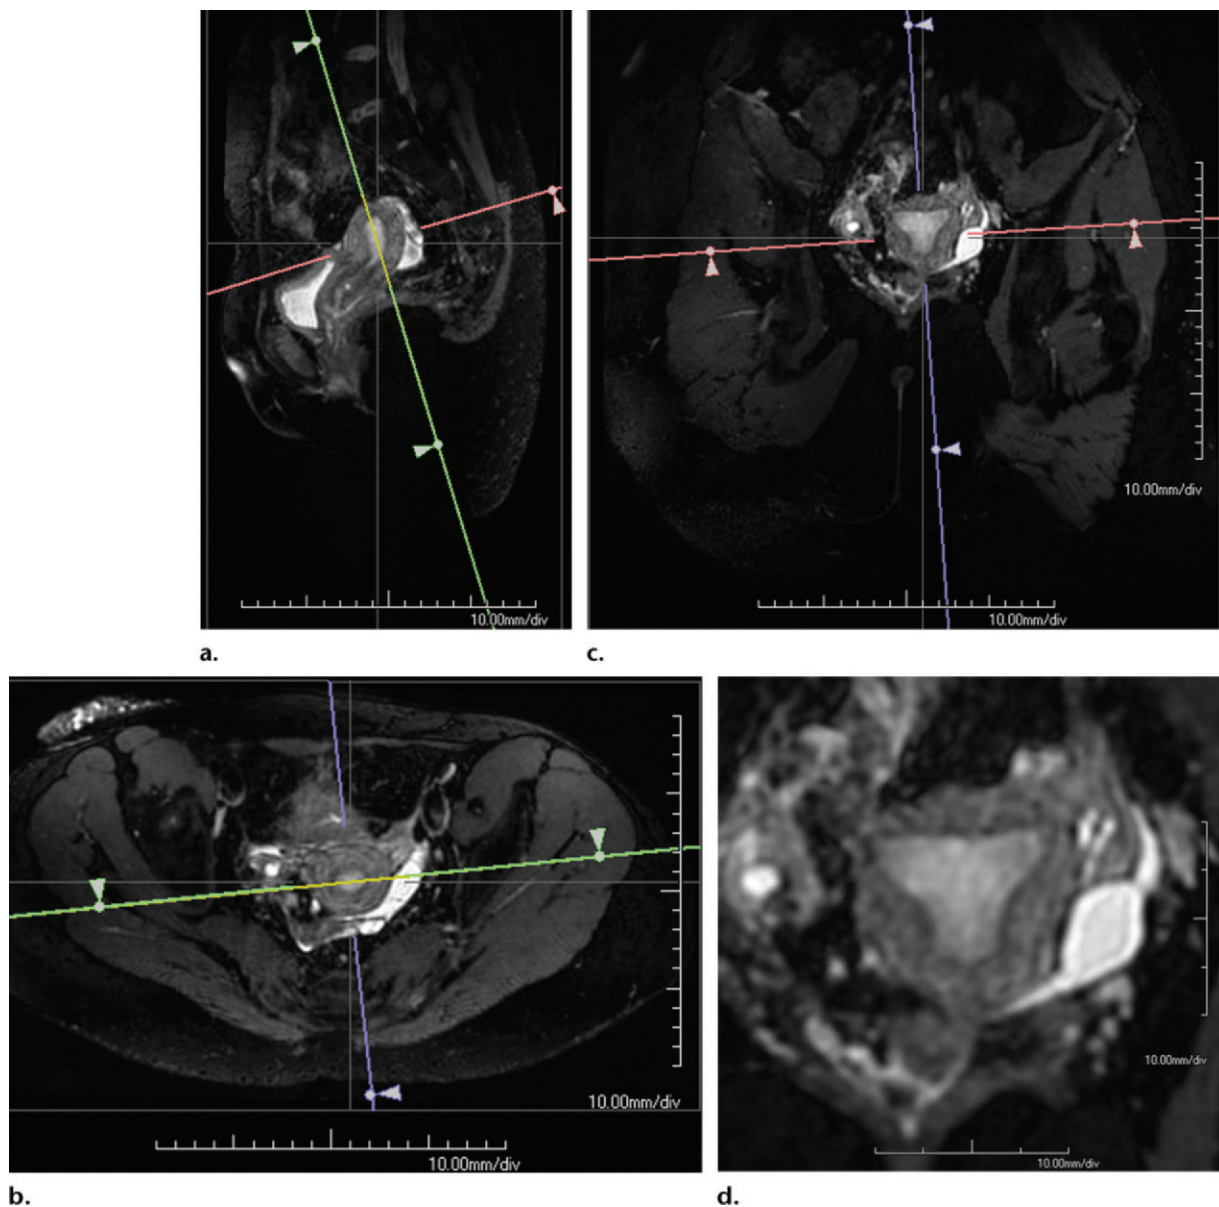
(a–c) Multiplanar reconstructions from 3D T2-weighted MR imaging show a normal uterus in sagittal (a), axial (b), and true coronal (c) projections of the pelvis. (d) Oblique coronal reconstructed image in a coronal plane to the uterus shows normal uterine fundal contour.
